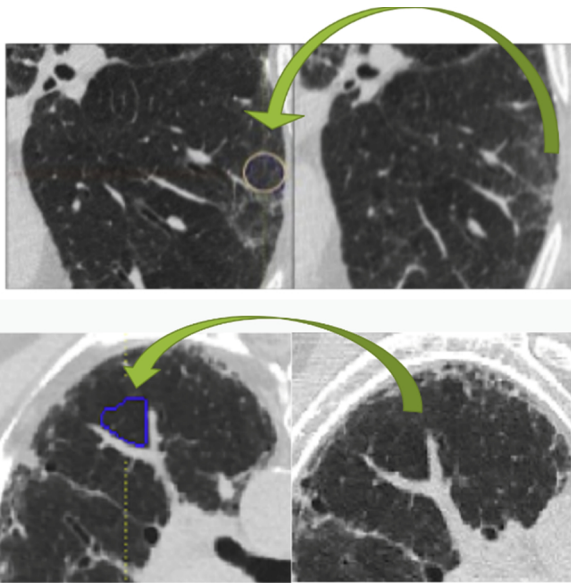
a (top). The baseline and follow-up HRCT of an IPF subject (progression): a radiologist compared a pair of set of HRCT and chose a classic representative small region and labelled the progression status based on the changes in imaging patterns. The contoured area in the HRCT scan at baseline is an example of region as *expected to be progressed*. Fig. 2b (bottom). The baseline and follow-up HRCT scans of an IPF subject (non-progression): similarly, a radiologist compared the baseline ROI and its anatomical match in the follow-up scan and determined the pattern as non-progression. The contoured area at baseline is contoured as an *expected to be stable (not-progressed)*.
